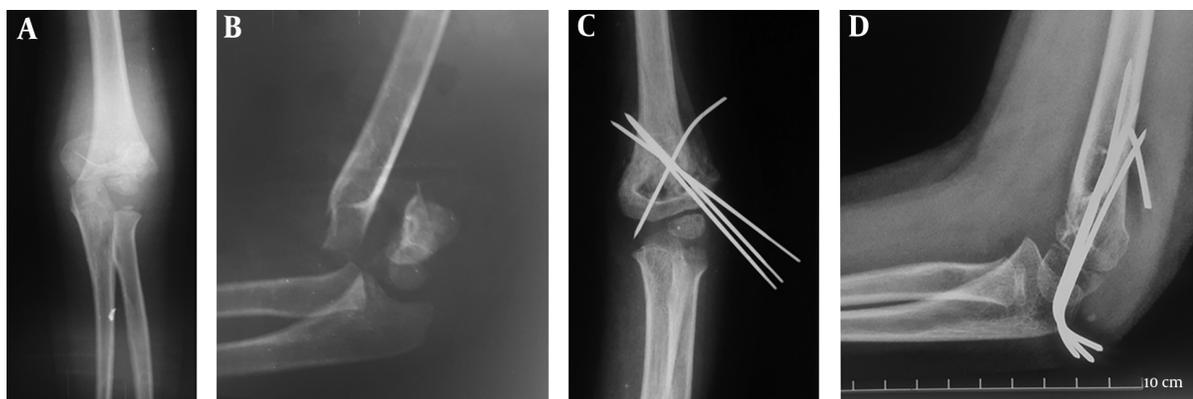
A, Preoperative AP X-Ray; B, Preoperative Lateral X-Ray; C, Postoperative AP X-Ray; D, Postoperative Lateral X-Ray
